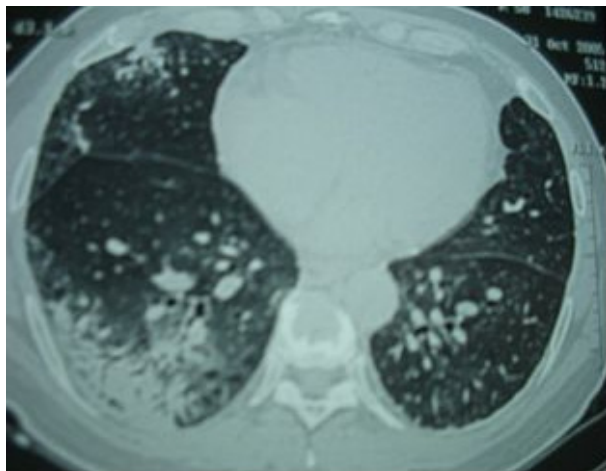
Ground glass opacities at right lung and moderate reticular appearances at peripherals with HRCT
